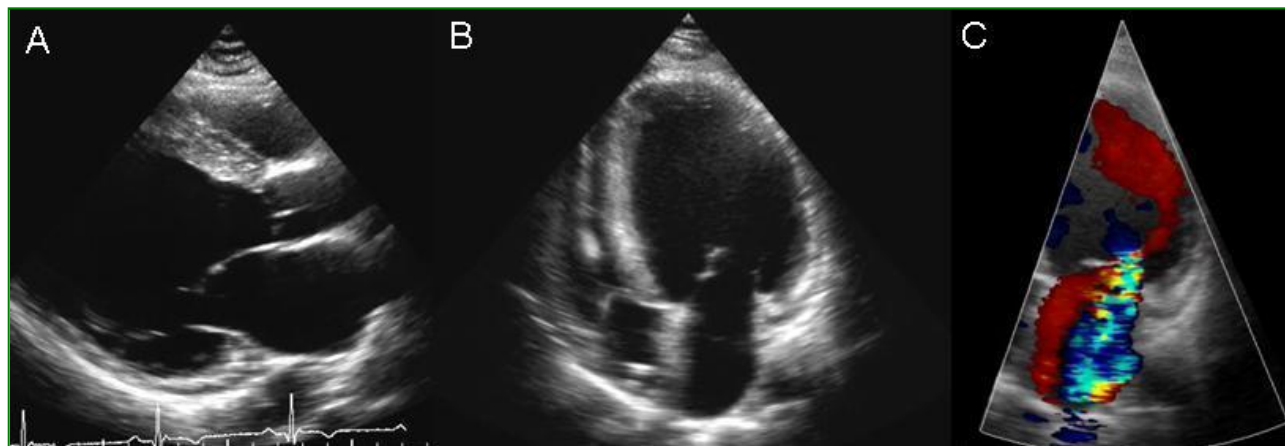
Echocardiogram of the proband. (A) Parasternal short axis view: left ventricle dilation, irregular echo-reflectance of the septum, thinning of the posterior wall, mild left atrium dilation. (B) apical four-chamber view: left ventricular dilation, normal right ventricle; in the right ventricle evidence of the catheter of the ICD. (C) Color-Doppler from the apical four-chamber view showing the mitral regurgitation.
